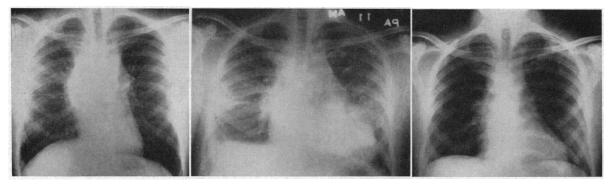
Film at left, taken 17 June, shows pronounced widening of the mediastinum and faint infiltrate extending out to lung fields. Center film, 23 July, shows progression to bilateral pulmonary infiltrates. A film taken 3 September (right frame) shows considerable regression of radiographic abnormalities—the lung fields essentially clear and the mediastinum not as wide as it had been for two and a half months earlier.
